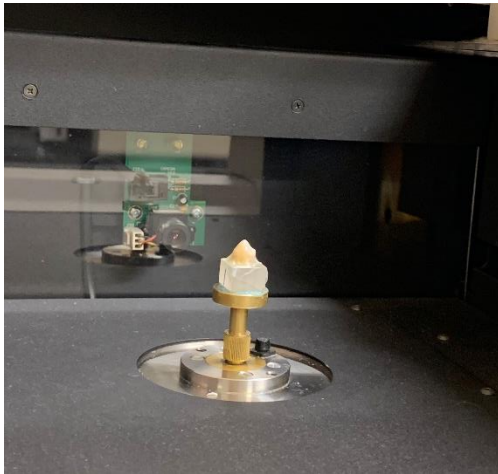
Sample covered with parafilm sheet and mounted on a Micro CT rotary stage.
